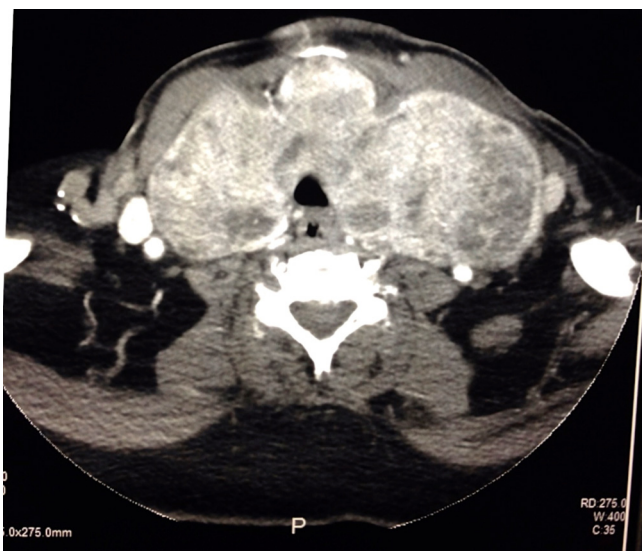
Transverse CT image.
